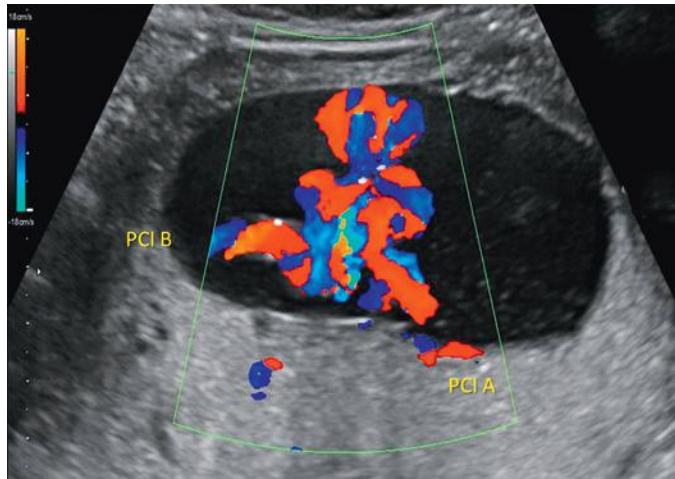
Color Doppler ultrasound image demonstrating entangled umbilical cords of monochorionic monoamniotic twins. PCI, placental cord insertion of twins A and B.
